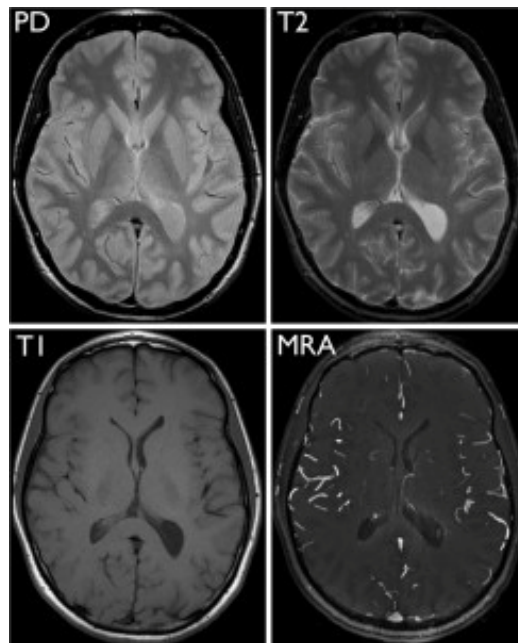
MRI images, with different contrasts, acquired at the same level in the same volunteer. Proton density (PD, top left), T1-weighted (T1, bottom left), T2-weighted (T2, top right), and MR angiography (MRA, bottom right). Image courtesy of <http://blog.radiology.ucsf.edu/>
